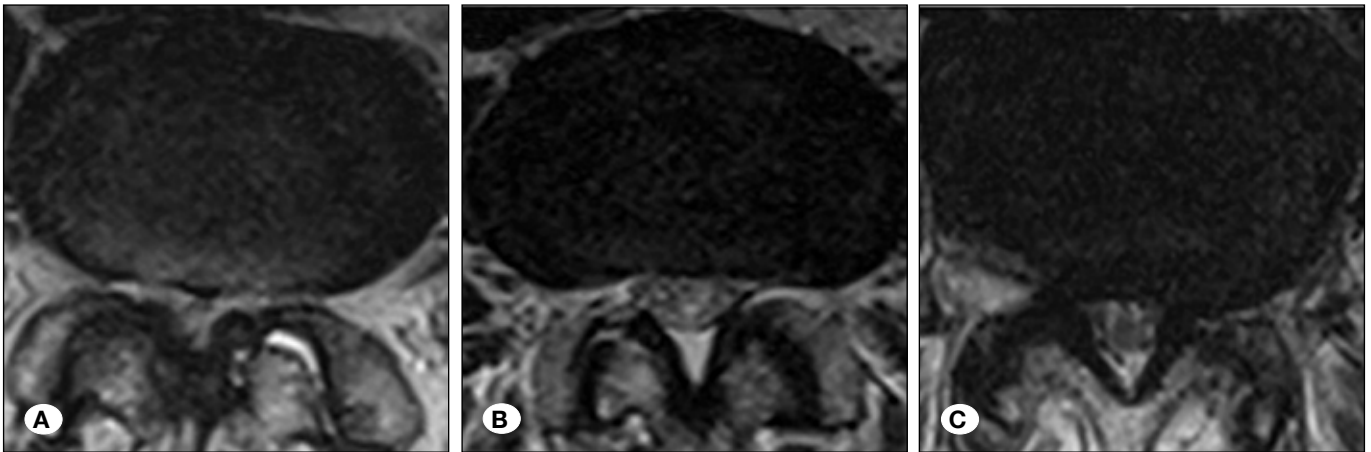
Representative magnetic resonance images demonstrating oval, circular, and triangular vertebral canal shapes.
